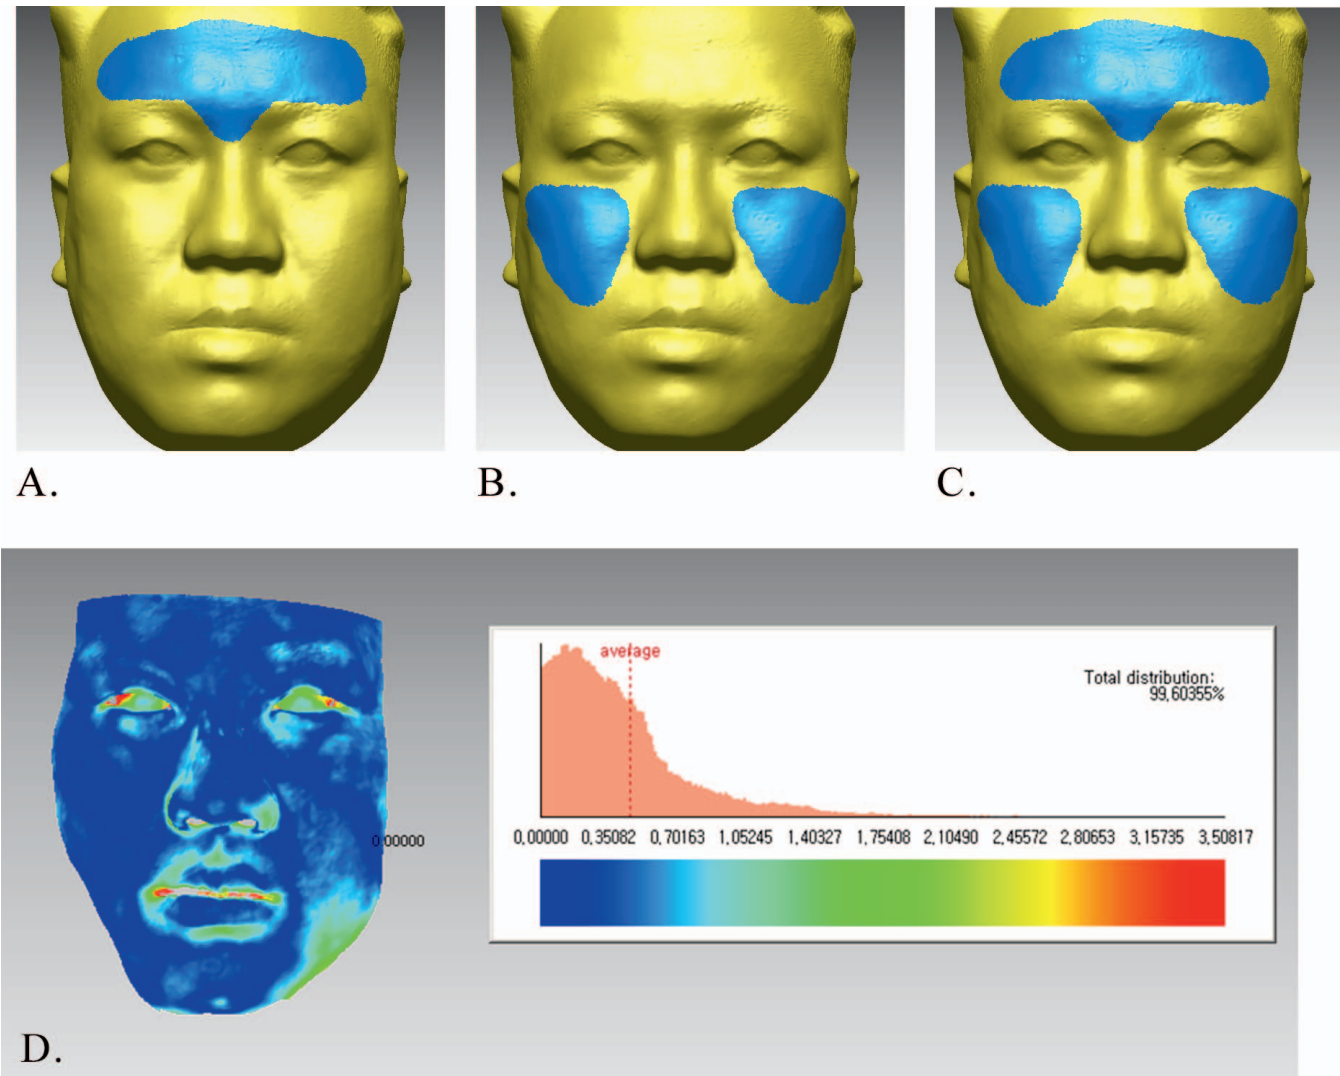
The blue-colored area depicts the registration area selected in each regional registration. (A) Forehead and nasal bridge only. (B) Malar area. (C) Forehead, nasal bridge, and malar areas. (D) Color-coded visualization charts show the differences between facial scans and CBCT images after the registration procedure.
